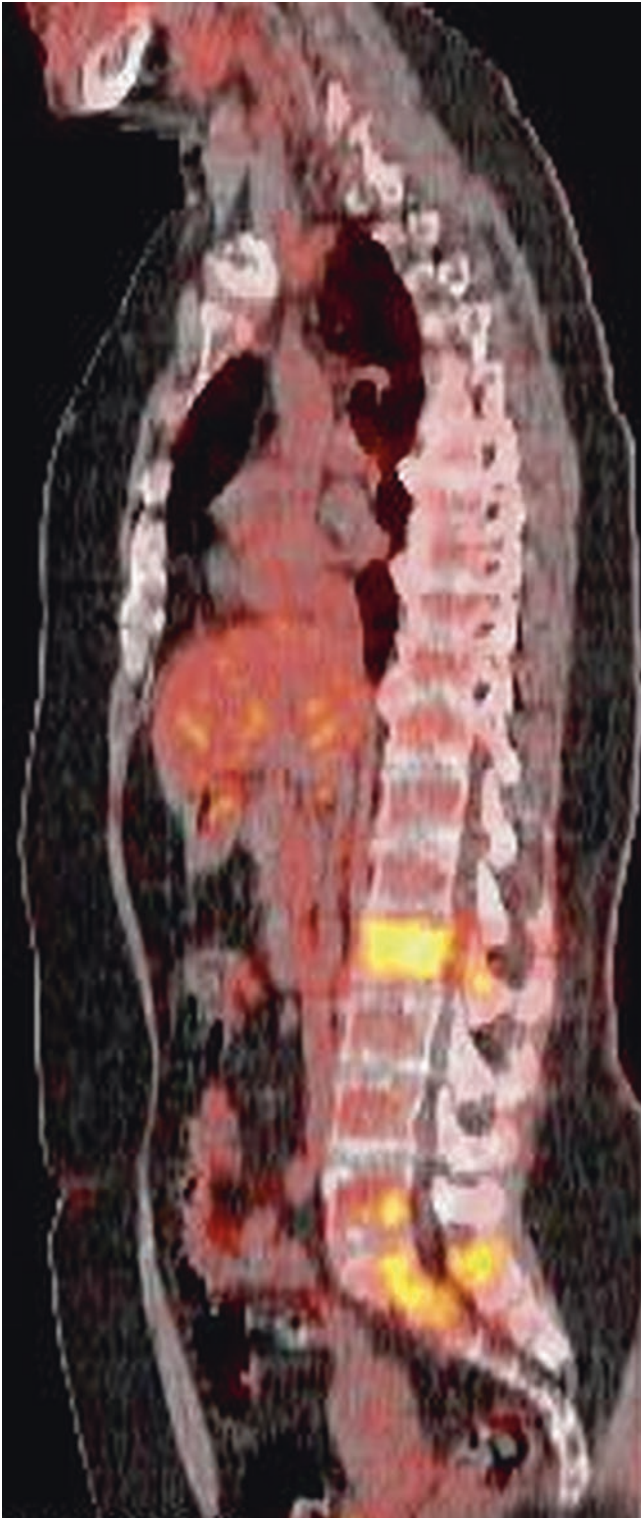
PET-CT scan of a 55-year-old woman revealing a metastatic lesion from breast cancer on the L2 vertebrae and sacrum
